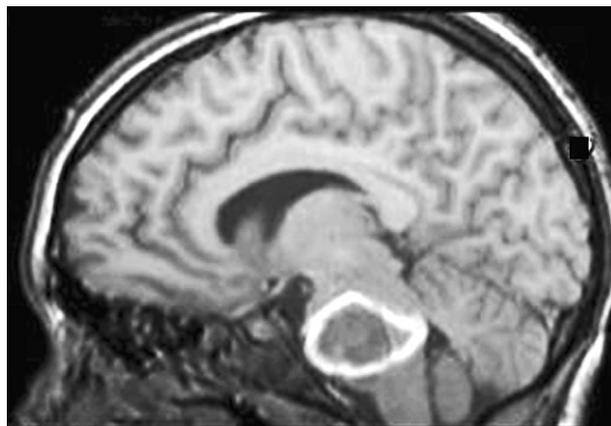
T_1 -weighted magnetic resonance imaging (sagittal section) reveals a massive hemorrhage in the brainstem (circular hyperintense signal) (TR/TE = 1960/4 ms).
